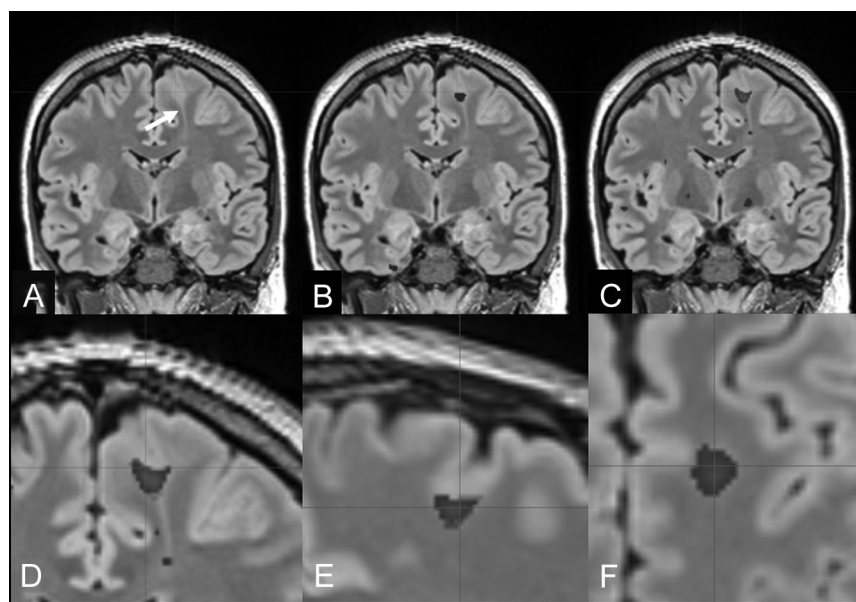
FCD IIb with a transmantle sign of the left superior frontal gyrus (bottom-of-sulcus dysplasia) in a 27-year-old man with right-sided sensory-motor seizures (patient 5). A, Reformatted 1-mm-thick coronal FLAIR section (*arrow*: transmantle sign of the FCD). B, Overlay of MPRAGE-based junction image abnormalities with z scores of >4 . C, Overlay of MP2RAGE-based junction image abnormalities with z scores of >4 . The MP2RAGE-based junction image matches the signal abnormalities at the gray matter junction as a characteristic feature of FCD type II (D–F, magnified coronal, sagittal, and axial views).
